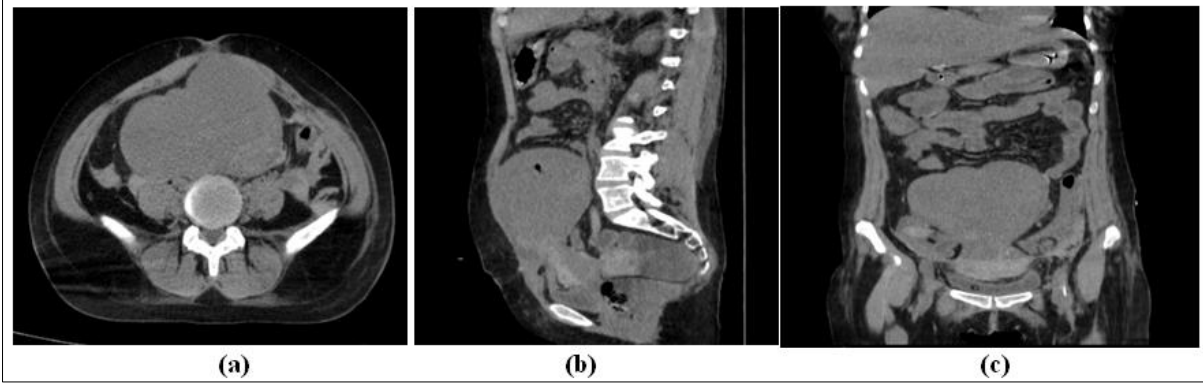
CT scan without contrast injection: axial (a), sagittal (b), coronal (c): globular hypodense uterus with intrauterine air bubbles
